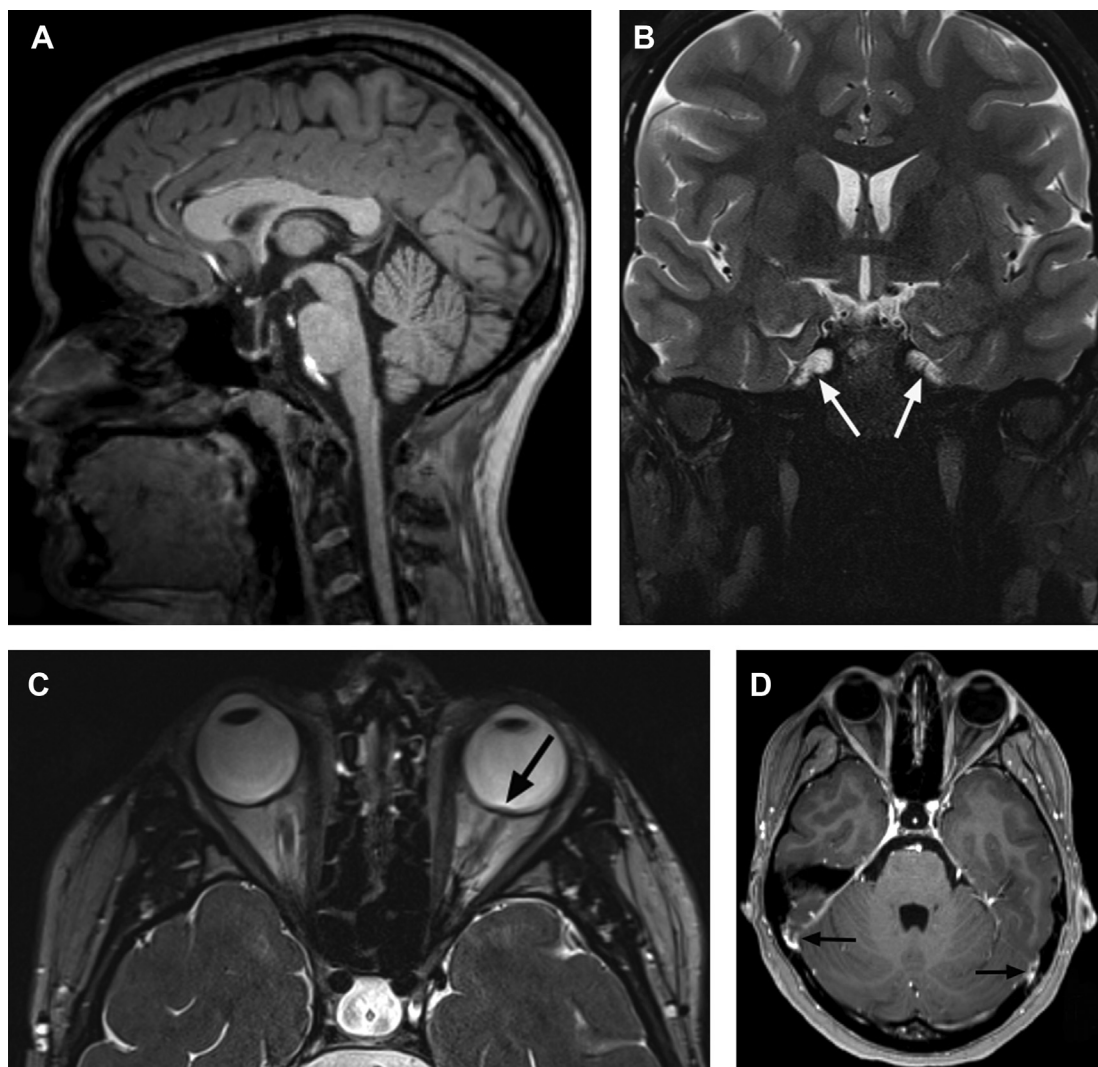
A 17-year-old girl with headache, blurry vision, and vomiting due to idiopathic intracranial hypertension. Sagittal 3D T1-weighted gradient echo image (A) demonstrates a partially empty sella. Coronal T2-weighted MR image (B) demonstrates enlarged Meckel caves (arrows). Axial T2-weighted MR image (C) demonstrates flattening of the posterior globes and subtle elevation of the left optic papilla (arrow). Axial postgadolinium T1-weighted 3D T1-weighted gradient echo (D) shows flattening of the transverse sinuses at the sinodural angle (arrows). There was no evidence of CSVT.
